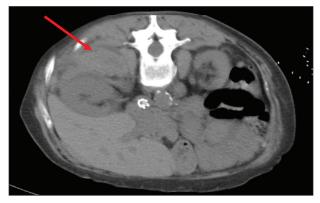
CT showing a large perinephric hematoma on the right (arrow).
